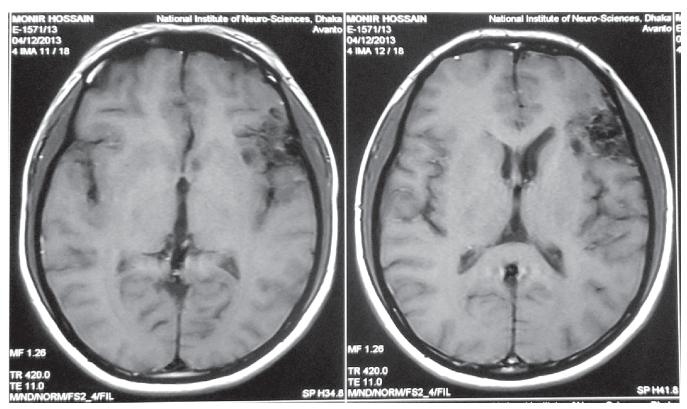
MRI with contrast showing AVM
